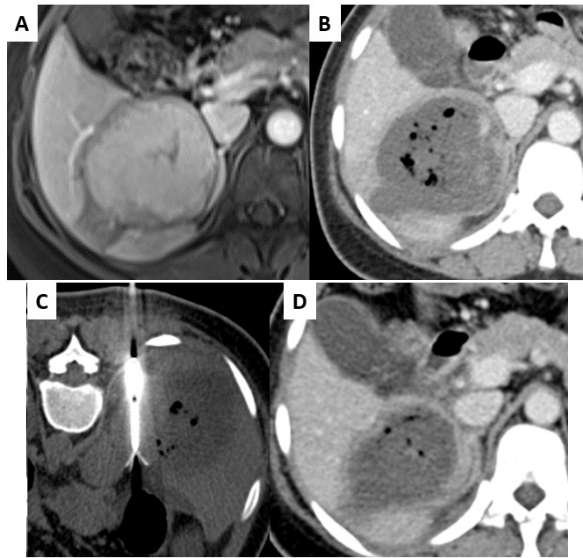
(A) Axial post-contrast MRI T1-weighted imaging showing enhancing large right lobe HCC. (B) Post-bicarbonate TACE, contrast CT showing significant necrosis with air pockets. Small persisting enhancement noted in medial part. This residual part of the tumor was treated with ablation (C,D) Follow-up CT showing complete response with persisting air pockets.
